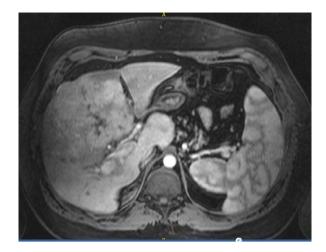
Magnetic resonance imagining (MRI), T1 sequence with fat saturation, without contrast, axial view. Tuberous mass visualized in right and left lobes of the liver
